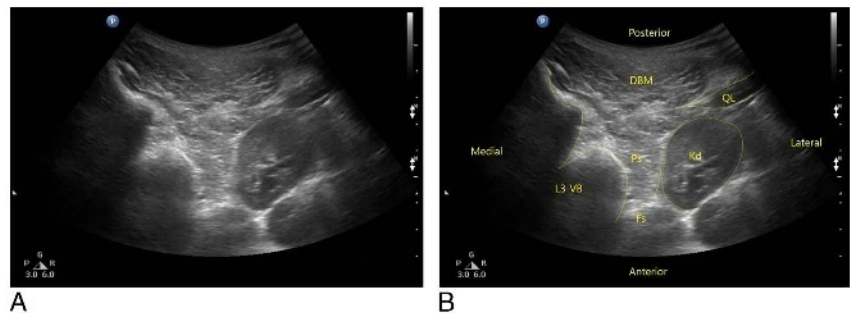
Transverse sonographic image at the level of the L3 vertebral body (VB) showing the psoas muscle (Ps), anterior fascia of the psoas muscle (Fs), quadratus lumborum (QL), kidney (Kd), and erector spinae (DBM).
